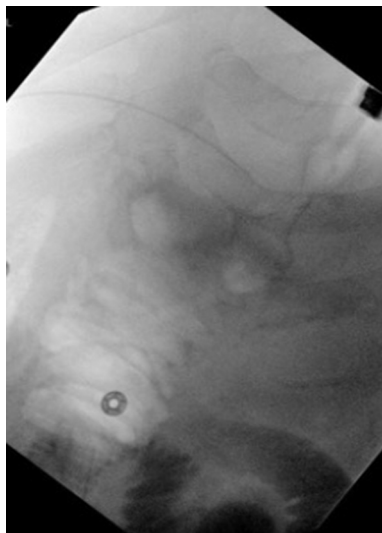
X-ray fluoroscopy showing stent in place from case 3.
